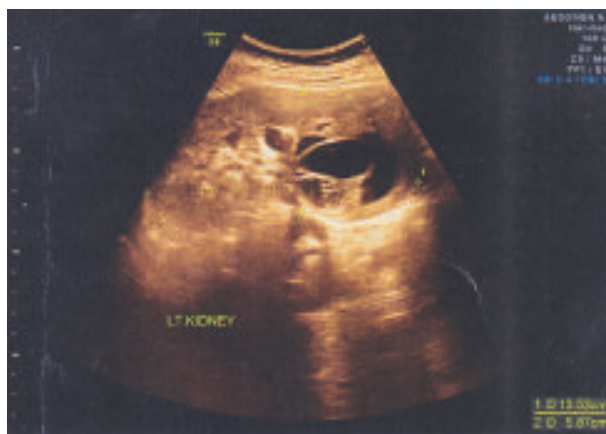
Ultrasound of left kidney
